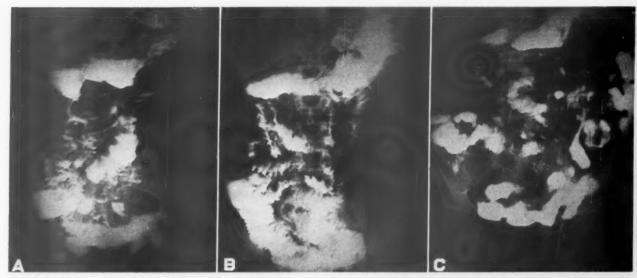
Roentgenograms of upper gastrointestinal tract and small bowel with aqueous barium sulphate suspension, demonstrating: (A) gastric and small intestinal hypersecretion with fluid levels; (B) thickened folds in stomach and small bowel; and (C) segmentation and flocculation of barium characteristic of the "deficiency pattern."
